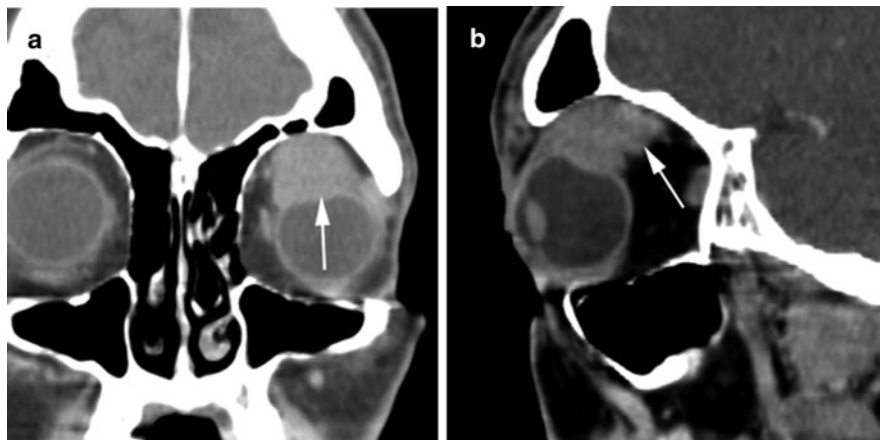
Synovial sarcoma, left orbit. (a) Coronal postcontrast CT demonstrates a lesion within the superior left orbit with impression upon and inferior displacement of the globe (*arrow*). (b) Sagittal postcontrast CT shows the superior left orbital mass (*arrow*) indenting the globe
